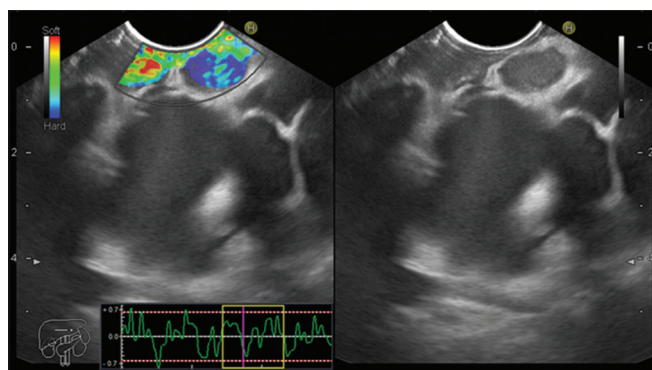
Mediastinal lymph node in a patient with pancreatic cancer - hard appearance in real-time elastography-endoscopic ultrasound
